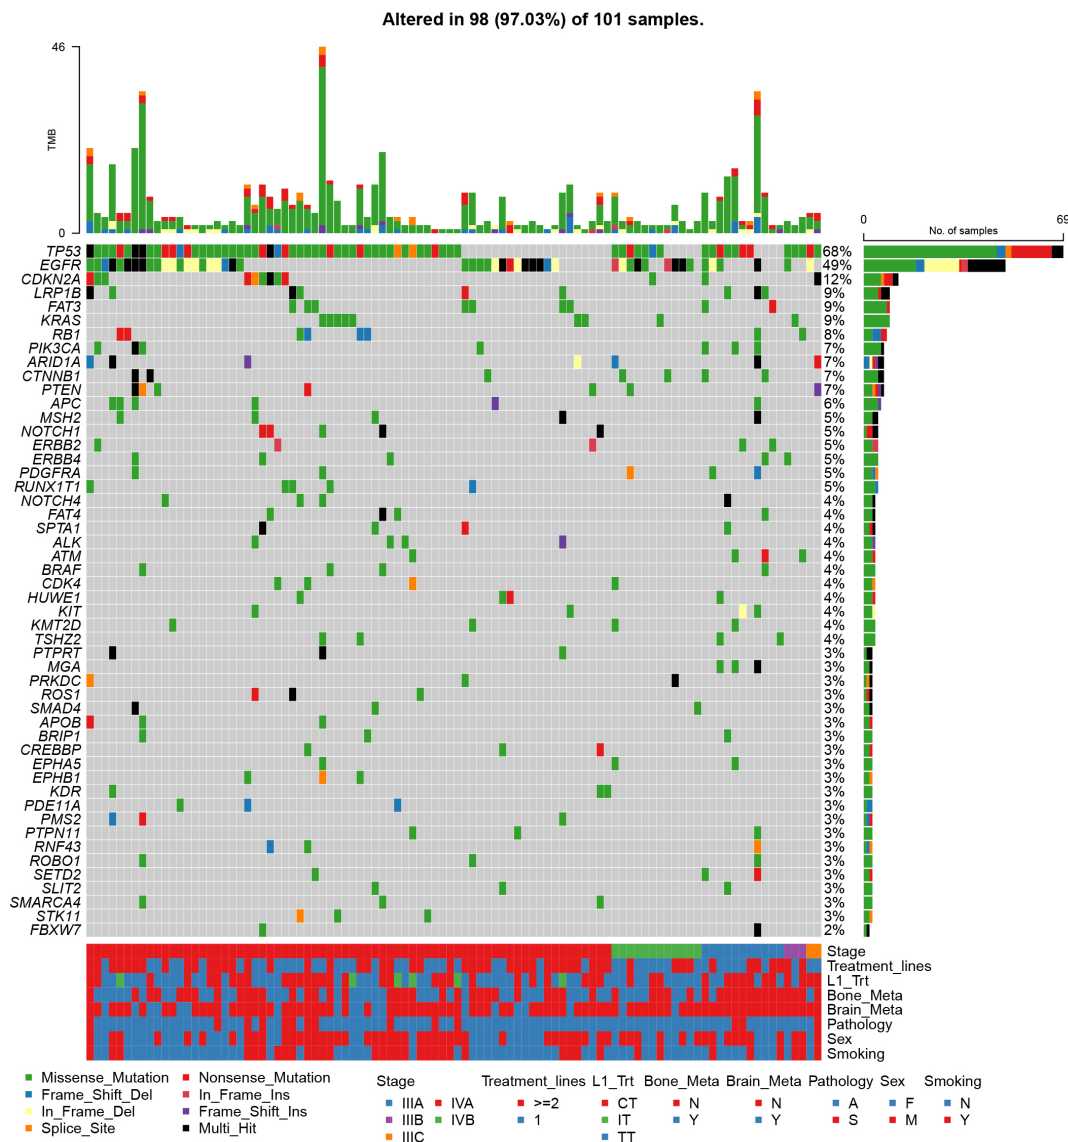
Mutation landscape of patients with stage III or IV non-small cell lung cancer (NSCLC) (n = 101). Each horizontal line represents a single gene, and each vertical line represents different samples. Different colors indicate the type of mutations. Representative clinical features of the patients, such as tumor stage, metastasis status, and sex, are shown at the bottom of the plot. N, no; Y, yes; F, female; M, male; A, adenocarcinoma; S, squamous cell carcinoma; CT, chemotherapy; IT, immunotherapy; TT, targeted therapy.
